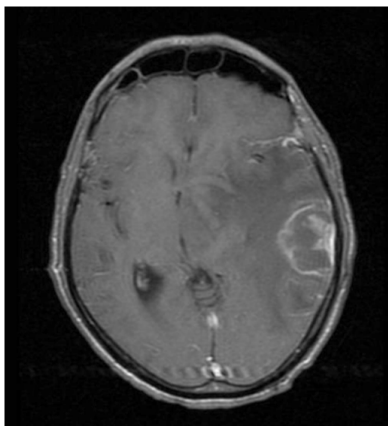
T1-weighted contrast-enhanced Magnetic Resonance Imaging (MRI). Brain mass measuring approximately 3.5 x 3.2 x 3.2 with lobulated margins located in the periphery of the left temporal lobe presenting with peripheral and central enhancement. There is extensive perilesional vasogenic edema and significant midline shift.
